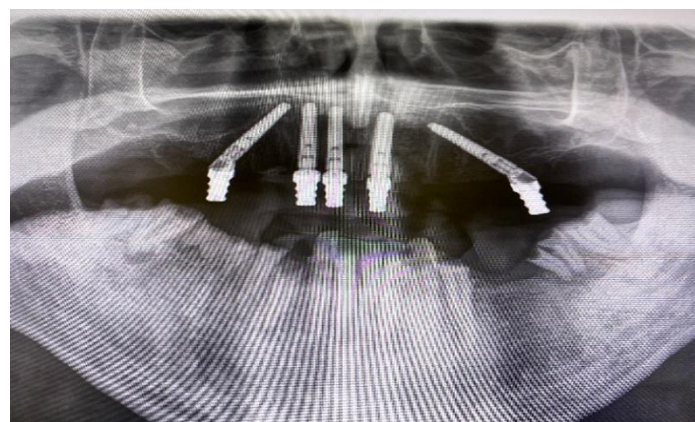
A post-operative panorama X-ray
